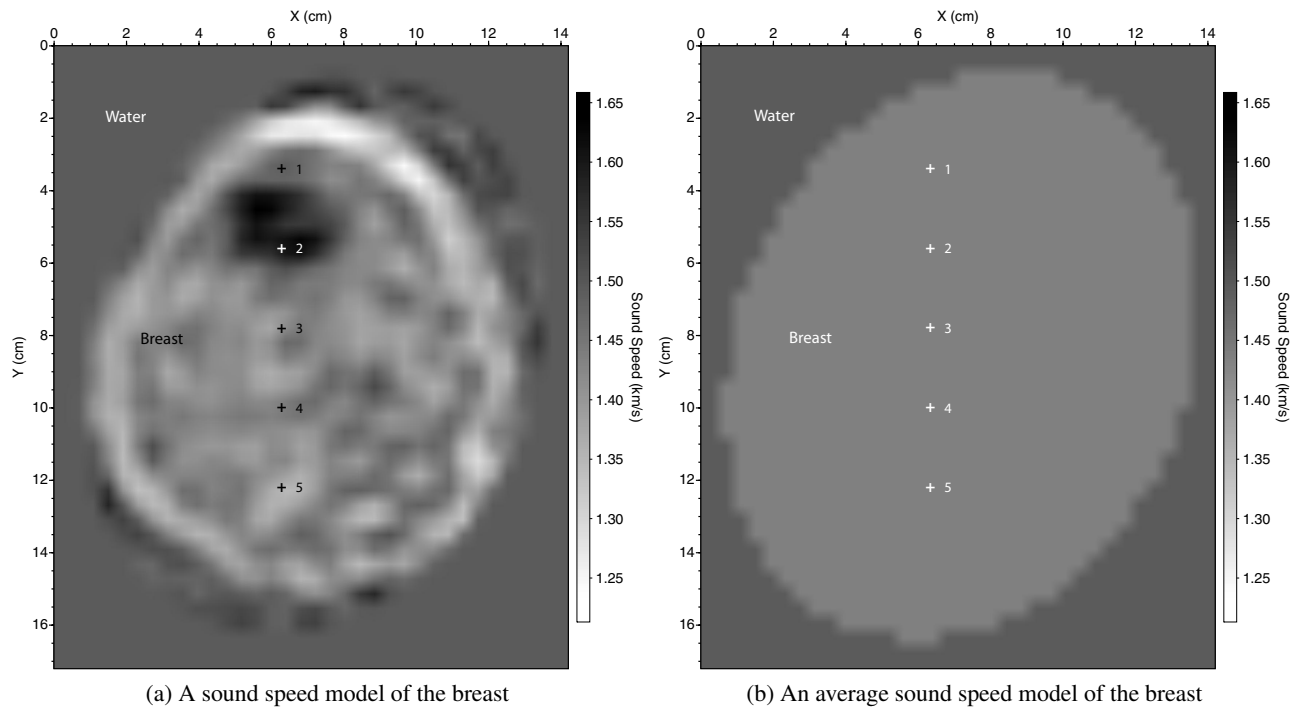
(a) A breast sound-speed model obtained from ultrasound tomography of an *in-vivo* dataset. (b) A breast sound-speed model with a constant sound-speed within the breast. The constant sound-speed in (b) is the average sound-speed within the breast in (a).
